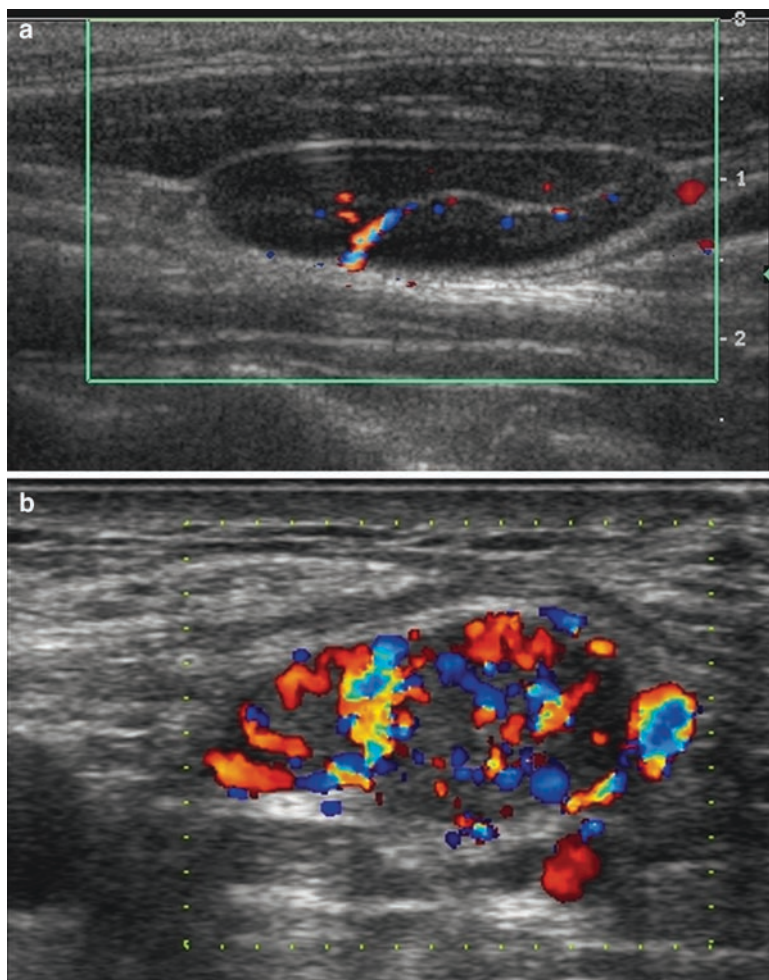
Normal and abnormal color flow Doppler. (a) Normal centrally located internal Doppler signal. (b) Grossly abnormal increased internal vascular flow typical of metastasis. (Images courtesy of Beth S. Edeiken, M.D.)
